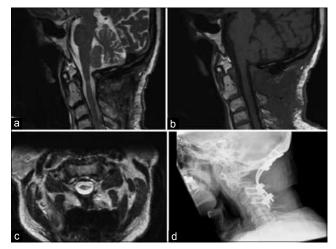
(a) T2-weighted sagittal magnetic resonance imaging of cervical spine showing disappearance of the retro-odontoid mass following occipitocervical fixation. (b) T1-weighted sagittal magnetic resonance imaging of cervical spine showing disappearance of the retro-odontoid mass following occipitocervical fixation. (c) T2-weighted axial magnetic resonance imaging of cervical spine showing decompressed spinal cord following disappearance of the retro-odontoid mass. (d) Lateral cervical spine X-ray showing occipitocervical fixation
